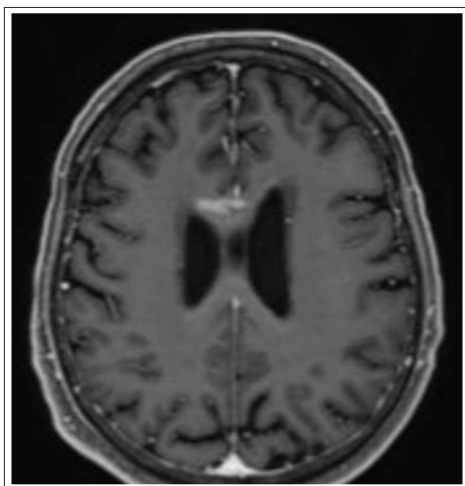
T1 weighted MRI brain demonstrating enhancing lesions within the body of the corpus callosum
